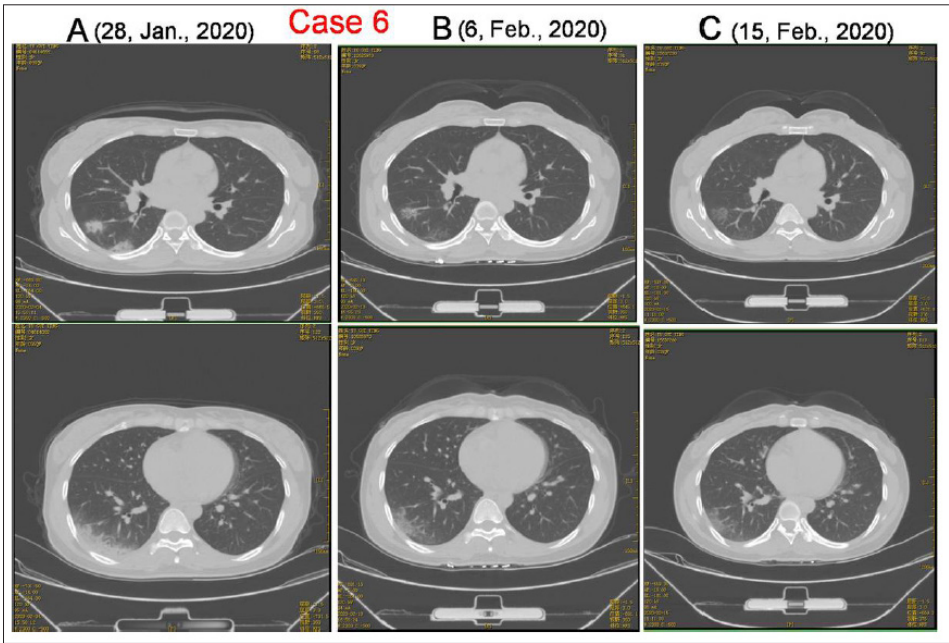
Chest CT Imaging of Patient 6
